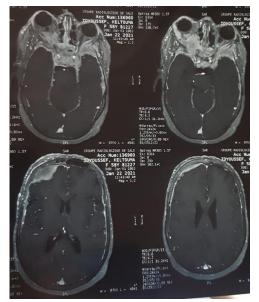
MRI image showing meningeal metastases +exophthalmos
